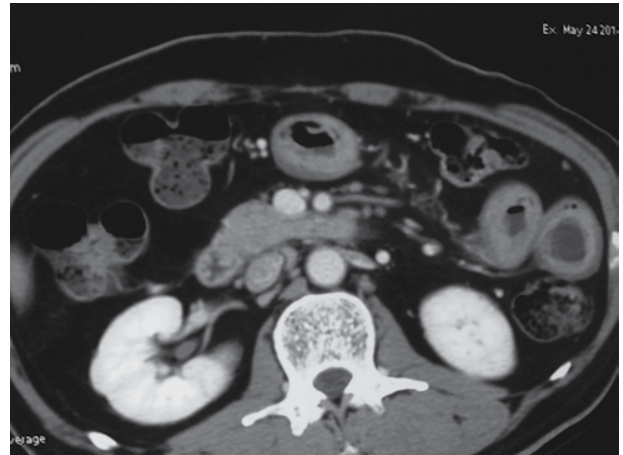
Edema of intestines on CT scan of abdomen.
